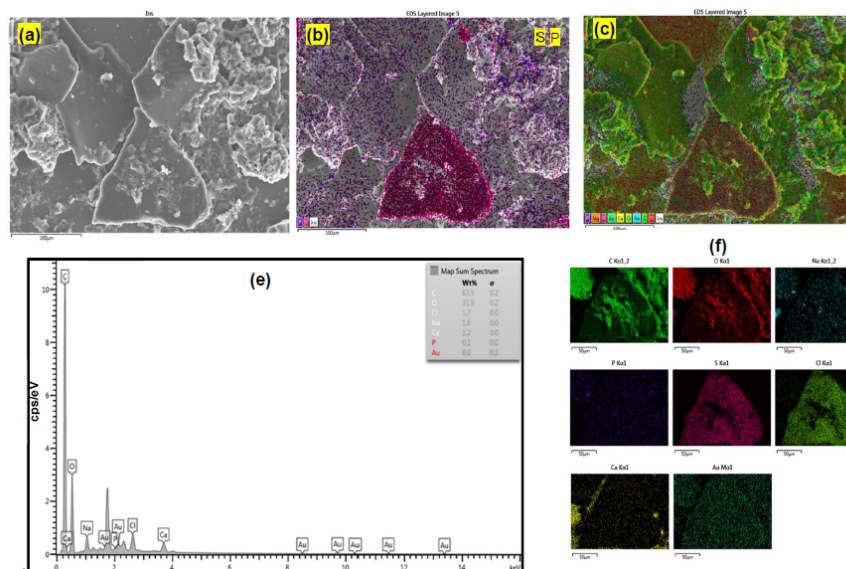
X-ray dispersive and SEM images show recombinant proteins, mAb, and CBD on dried MIP layers after post-transfection flow through the organic-aqueous mixture. Nanoscale HSA carriers and atomic-resolution measurements highlight the roles of temperature and composition in protein-CBD interactions. (a) SEM of CBD-enriched MIPs, (b) elemental mapping, (c) stacked mapping, (d) contrast SEM, (e) elemental binding energies; (A) EDX line scan of elemental emissions for internal fluorescent protein mapping.
